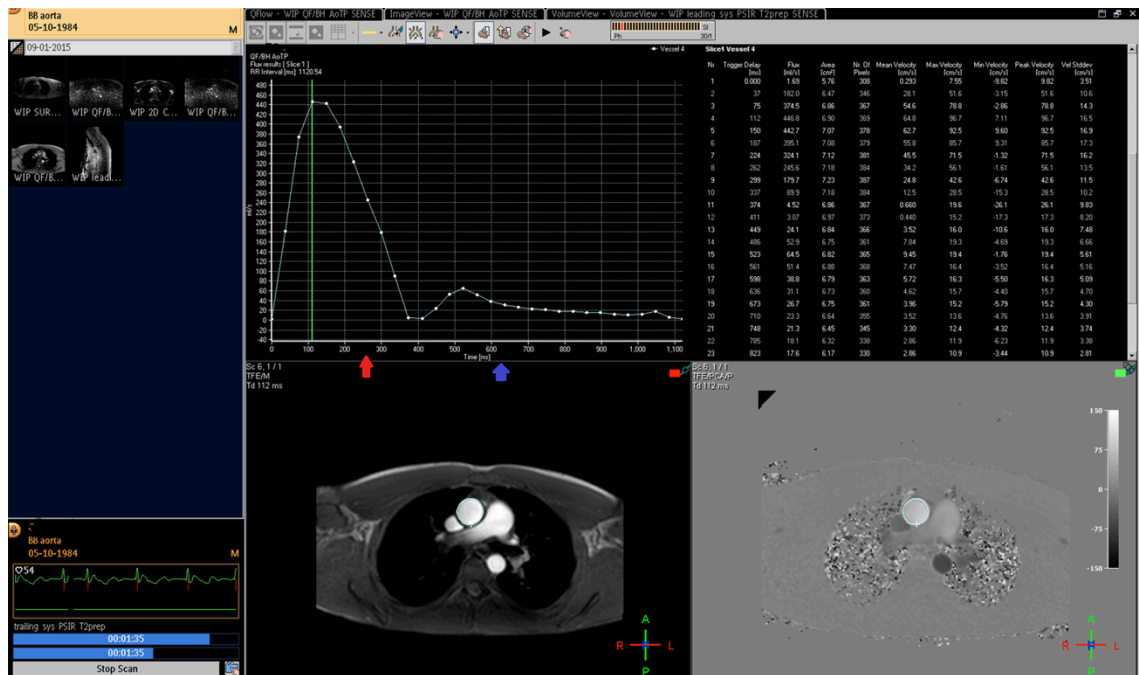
AN ALTERNATE STRATEGY OF INCLUDING A CINE IMAGE WITH DYNAMIC CARDIAC IMAGING TO DETERMINE SYSTOLE AND DIASTOLE WAS INCLUDED IN ADDITION TO CALCULATING FLOW IN THE ASCENDING AORTA ABOVE THE LEVEL OF THE AORTIC VALVE WITH PC-MRI. SYSTOLIC IMAGING WAS THEN TRIGGERED AS SHOWN BY THE RED ARROW AND DIASTOLIC BY THE BLUE ARROW.
